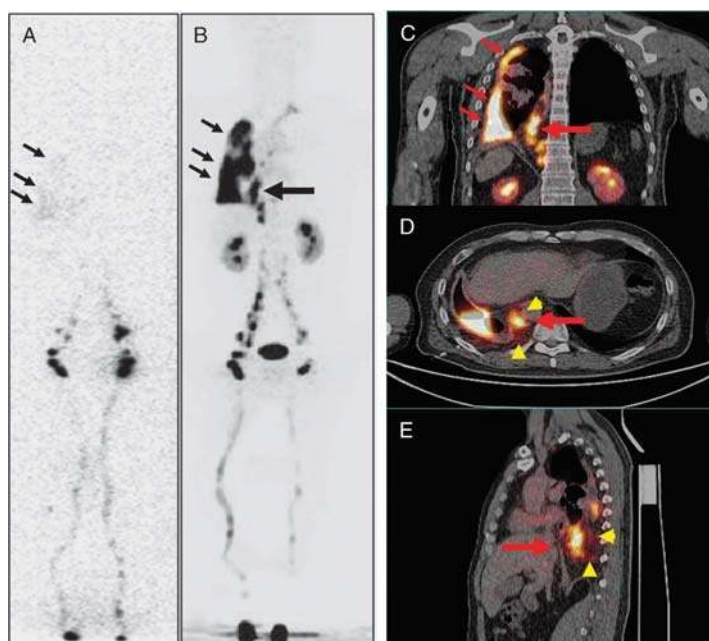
A 43-year-old man with the right side of persistent pleural effusion (patient 3). The patient had a remote history of motor vehicle accident. Laboratory examination of the fluid after thoracentesis demonstrated chylothorax. ^{99m}Tc-SC scintigraphy (A) revealed diffuse, mild activity in the right chest, consistent with the clinical findings of right chylothorax. However, the potential site of the chyle leak could not be identified. In comparison, ⁶⁸Ga-NEB PET/CT (B, MIP; C: coronal fusion; D: axial fusion; E: sagittal fusion) not only showed activity in the right chest pleural effusion (small arrows), but also clearly revealed an additional vertically linear intense activity (large arrow) centered in the dilated thoracic duct and cisterna chyli with mild activity surrounding (arrowheads), consistent with the site of the leak.
